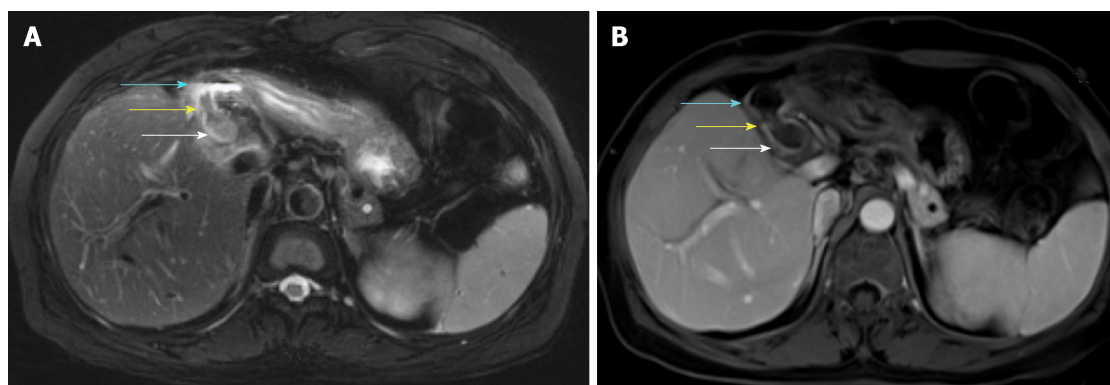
Magnetic resonance imaging. A: Axial T2 weighted image showing a fistula connecting the bile duct (white arrow) and the duodenal bulb (blue arrow) which had a gas-liquid plane inside. Inside the fistula, there was a hypointense lesion (yellow arrow); B: Axial T1 weighted image contrast enhanced showing no enhancement of the bile duct (white arrow), duodenal bulb (blue arrow), or lesion (yellow arrow).
